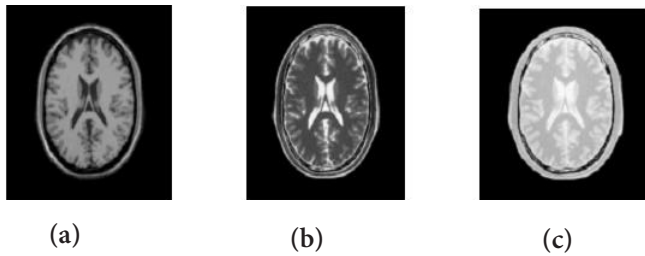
(a) T1 of MRI. (b) T2 of MRI (c) PD of MRI.
